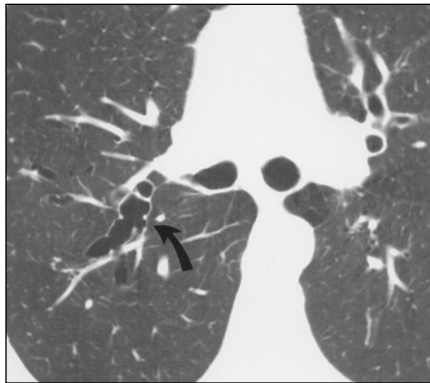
Allergic bronchopulmonary aspergillosis in 41-year-old man with severe asthma. Thin-section CT scan (1.5-mm collimation) reveals central varicoid bronchiectasis (*arrow*).
